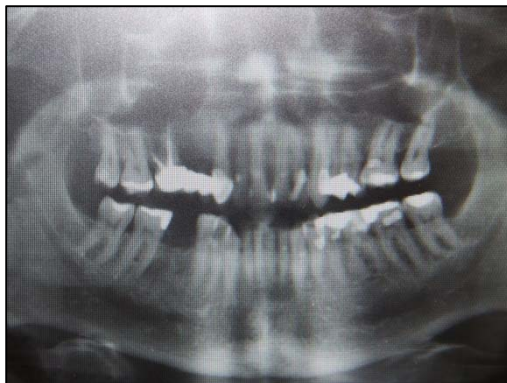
Panoramic radiograph at examination
